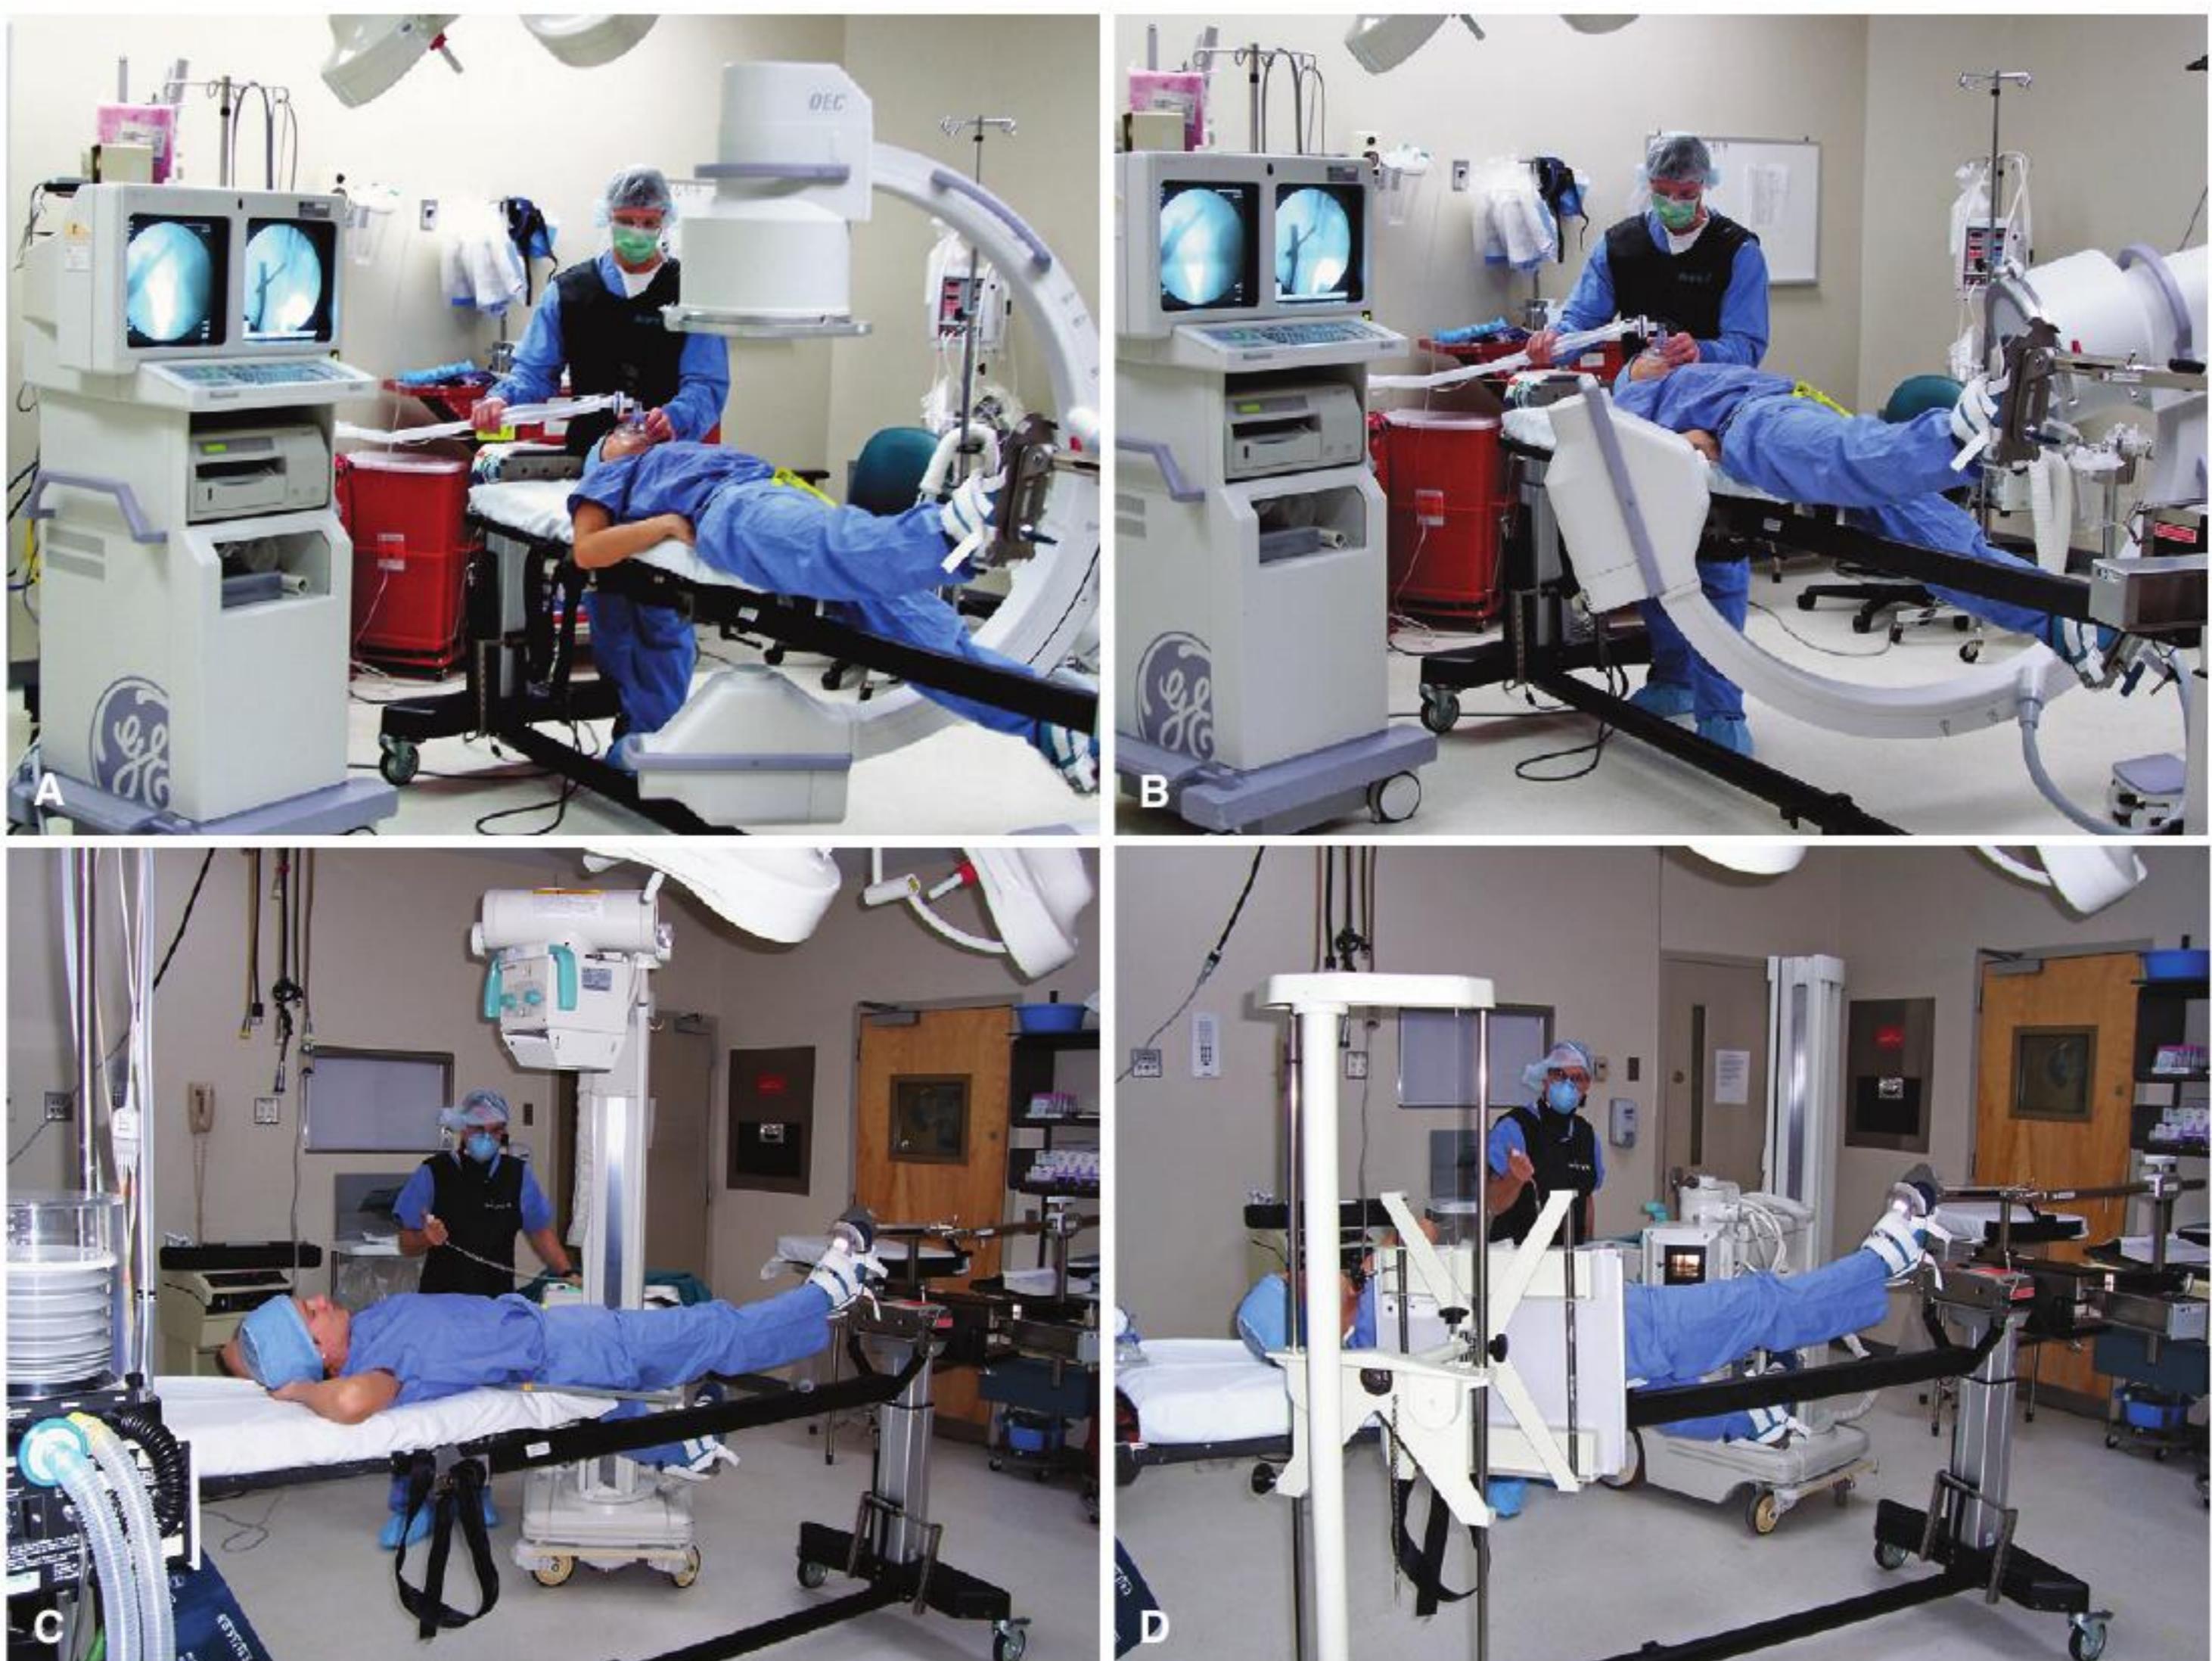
A and B, Portable C-arm image intensifier television fluoroscopy setup for fracture repair. C-arm rotates 90 degrees to obtain lateral view. C and D, Technique for two-plane radiographs during hip surgery with a portable machine for anteroposterior and lateral views. Film cassette for lateral view is positioned over superolateral aspect of hip.
